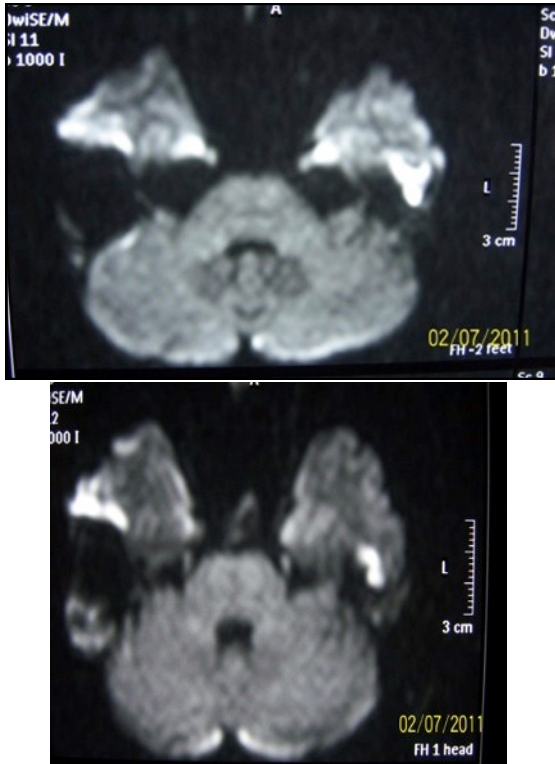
Diffusion MRI image of cholesteatoma
